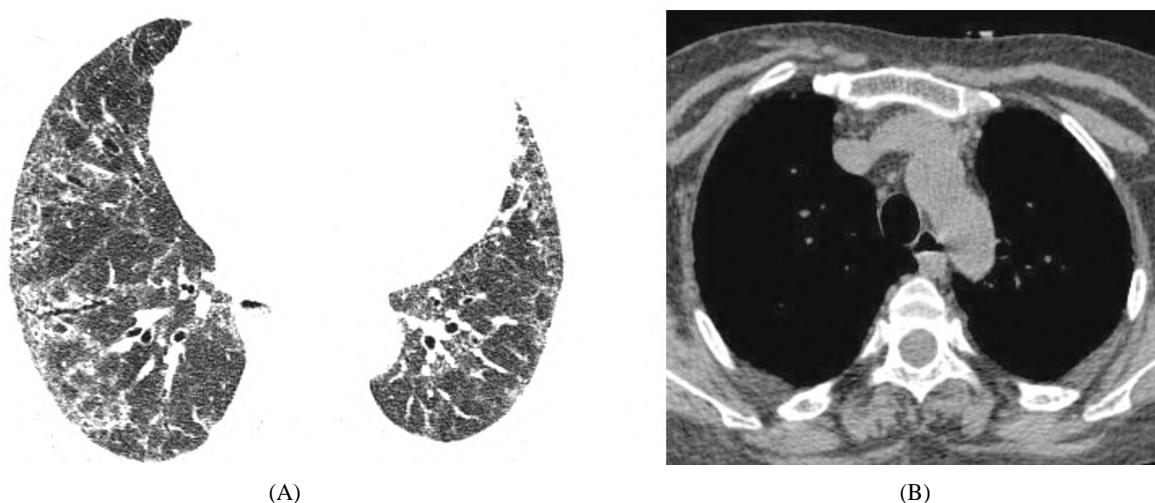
53-year-old female patient known case of Scleroderma presenting with dyspnea on minimal exertion and dry cough. (A) Axial HRCT image shows bilateral fairly symmetrical subpleural ground glass opacification and reticulations with traction bronchiolectasis suggesting fibrotic NSIP. (B) Axial mediastinal image show patulous esophagus with air fluid level within.
